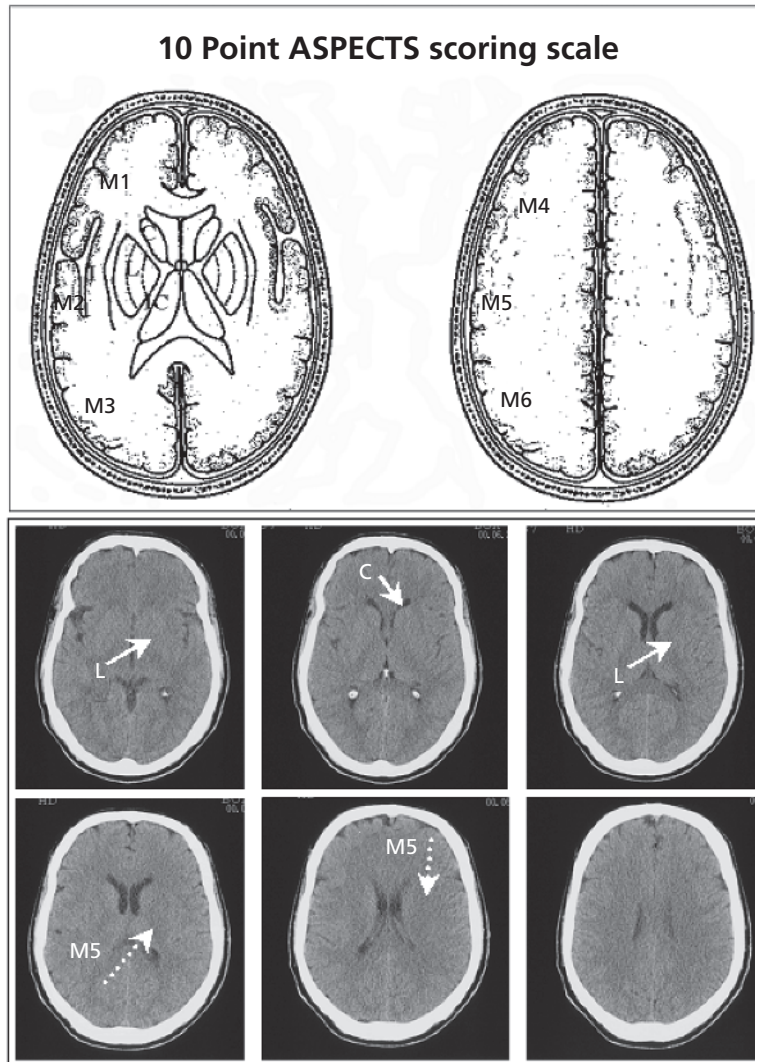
Alberta Stroke Program Emergent Computed Tomography Score (ASPECTS). A ten-point scoring system that focuses on the MCA territory over three ganglionic and three supraganglionic cuts. Each specific area is marked: I, insular ribbon; C, caudate nucleus; L, lentiform nucleus; IC, internal capsule; and M1, M2, M3, M4, M5, and M6 areas (this should not be confused with the order of MCA branches on angiography). If none are affected, the ASPECTS score is a maximum of 10 points.
